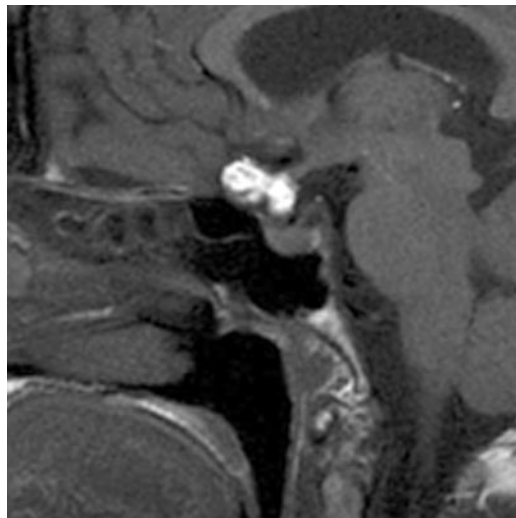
Subarachnoid remnants of contrast material in a 72-year-old woman with a history of intrathecal injection of an iodinated lipid-containing contrast agent for better visualization of a meningeoma (arrow) in the foramen magnum. Sagittal T1-weighted image shows multiple hyperintense nodules trapped in the chiasmatic cistern (arrowheads).
